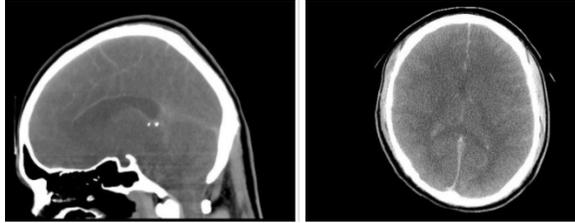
CT head plain showing diffuse cerebral oedema and complete effacement of cortical sulci, ventricles, and basal cisterns along with tonsillar herniation
